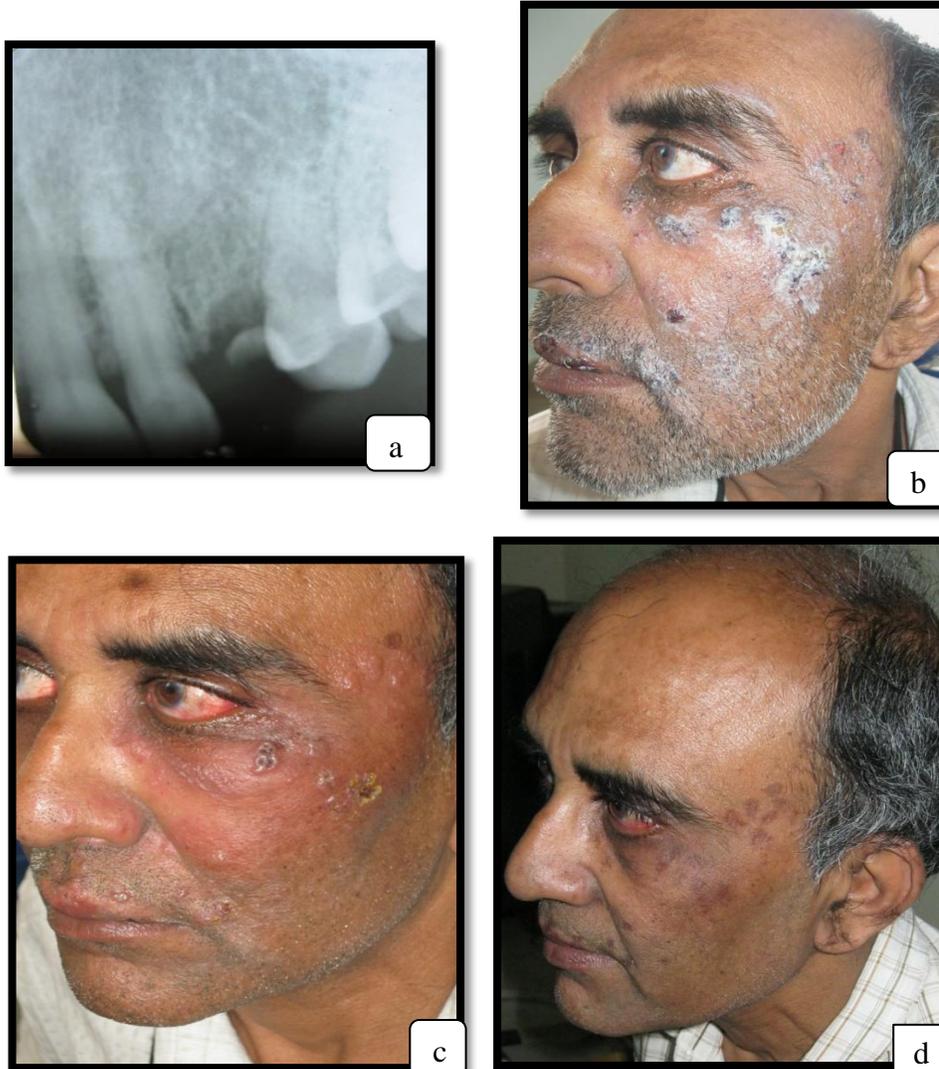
a) Intra oral periapical radiograph of 23 region showing root stumps, b) photograph on Day 2, c) photograph on Day 7 and d) photograph after 1 month
